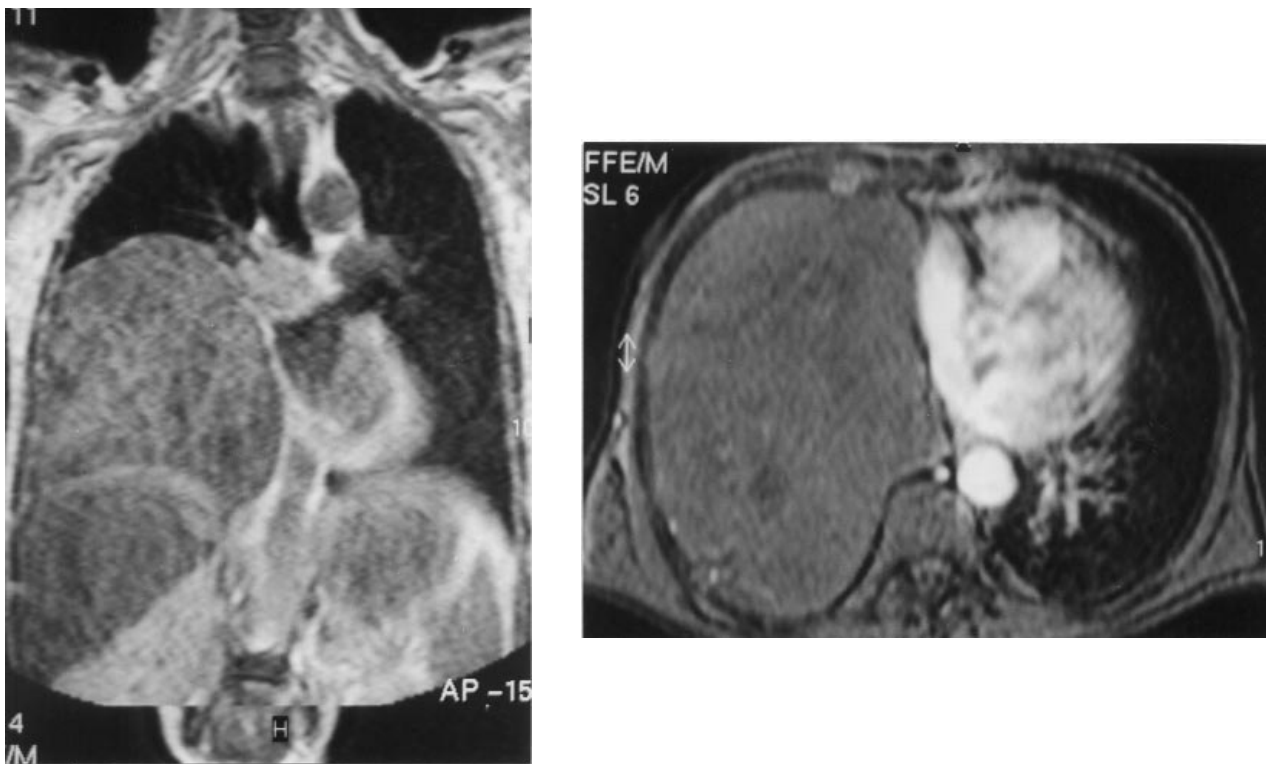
Axial (A) and coronal (B) T1 weighted magnetic resonance imaging of the chest shows a mass homogeneous in density in the right hemithorax.
